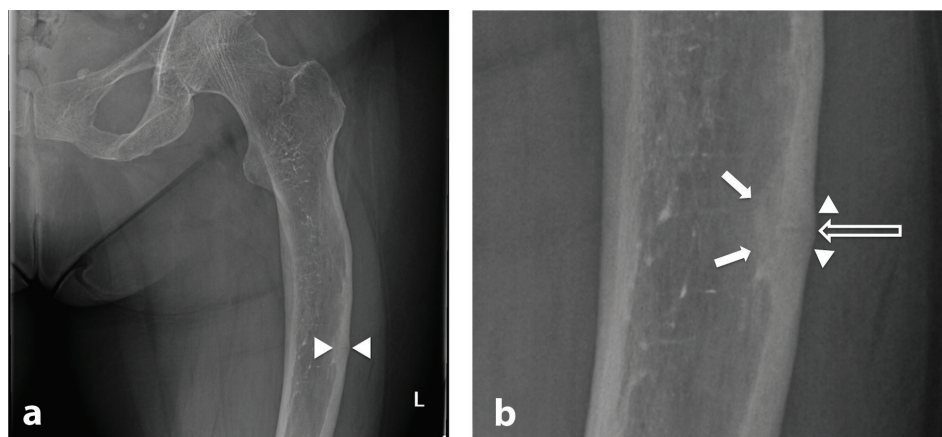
(a) X-ray of the pelvis and hip showing left incomplete diaphyseal atypical femur fracture and bowing of bilateral proximal femurs; (b) magnified image showing transverse fracture line (open arrow) originating from lateral cortex with localized endosteal thickening (solid arrows) and periosteal reaction (arrowheads).
